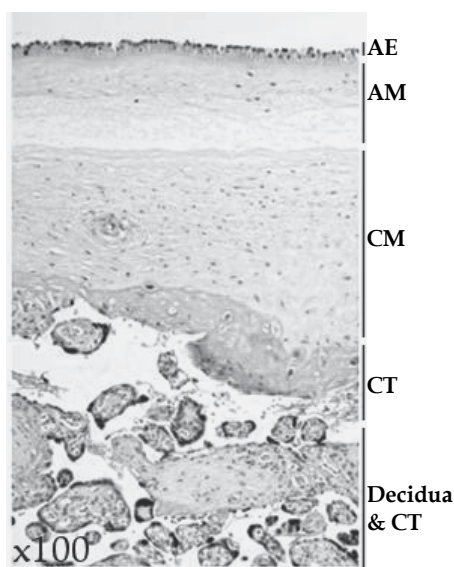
Cross-sectional representation of the human placenta. The amnion and chorion are fetal-derived membranes while the decidua is maternally-derived. The amniotic layer is composed of a single-celled epithelial layer and a deeper mesodermal layer. The chorionic layer is comprised of a mesodermal layer and a trophoblast layer. The maternal decidua is intermingled with the fetal chorionic trophoblast. (AE: amniotic epithelium; AM: amniotic mesoderm; CM: chorionic mesoderm; CT: chorionic trophoblast.)
